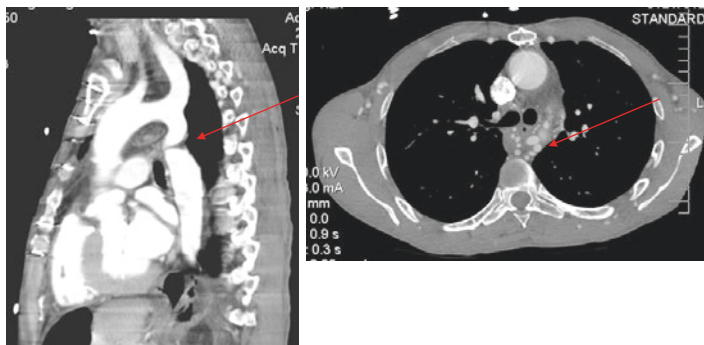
(Left) Depiction of discrete coarctation (red arrow) anatomy by CT angiography, sagittal section. (Right) Chest CTA, axial section, demonstrating prominent collateral flow axial imaging, small proximal descending aorta (red arrow) [2]
